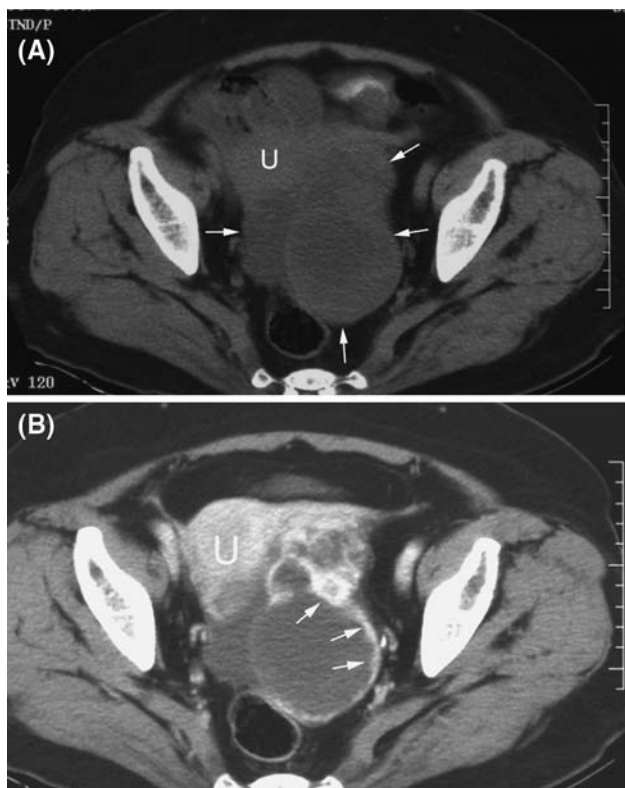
Struma ovarii in 67-year-old woman. A, Precontrast CT scan shows multicystic mass in the right ovary (arrows). Uterus (U). B. Contrast-enhanced CT scan shows marked cyst wall enhancement of multicystic mass (arrows)
